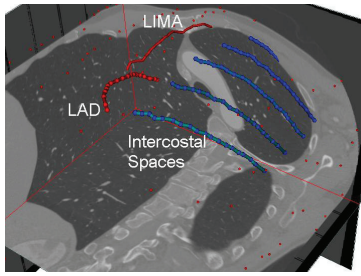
The surgical workspace localized using a CT-scan in an interactive 3D environment provided by Atamai Viewer.
